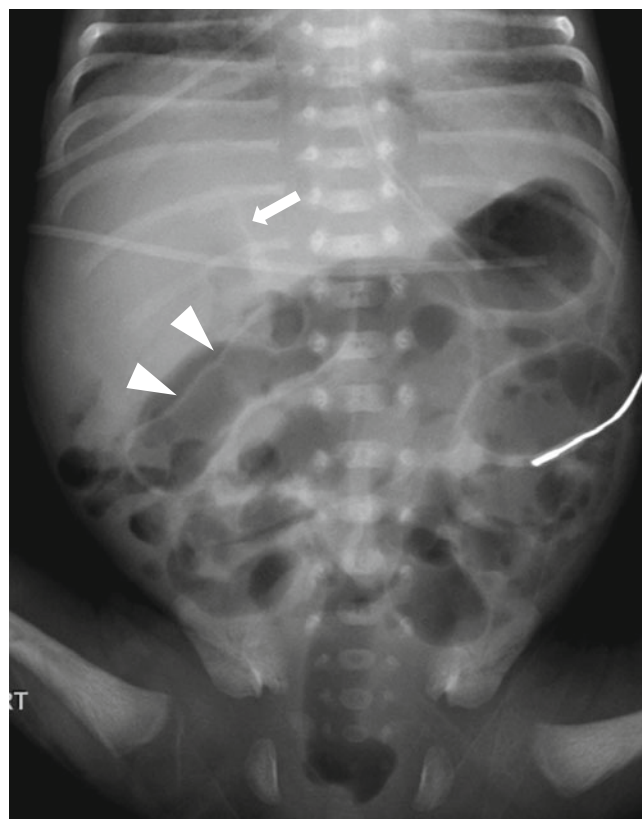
Pneumoperitoneum in necrotizing enterocolitis. Supine radiograph in a premature baby demonstrates hyperlucency in upper abdomen with visualization of falciform ligament (*arrow*), indicating presence of intraperitoneal free air. The free air also outlines the outer wall of the bowel (*arrowheads*), which is called as Rigler sign. There is moderate diffuse enteric distension with gas
